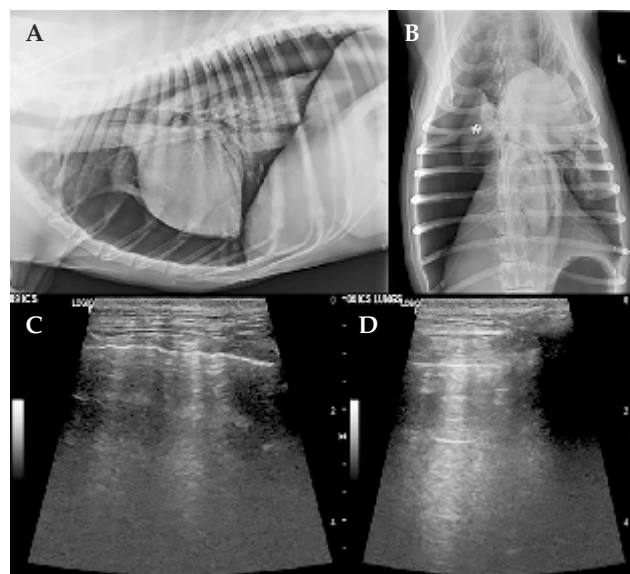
(A) Right lateral thoracic radiograph showing pneumothorax with lung retraction and increased radiolucency; (B) Ventro-dorsal thoracic radiograph showing collapse of right middle lung lobe '*'; (C) T-FAST revealed the presence of A-lines, indicative of air within the pleural space, at the 5th to 10th ICS confirming pneumothorax; and (D) T-FAST image showing lung sliding and B-lines, indicative of normal lung.
